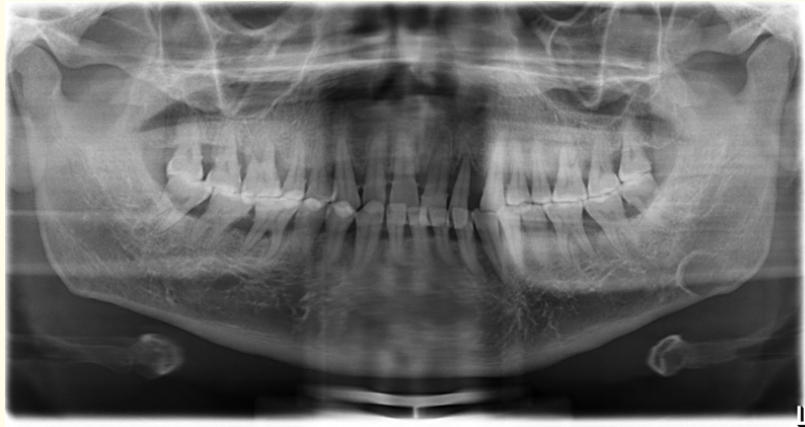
Orthopantomography (OPG) of case two.
